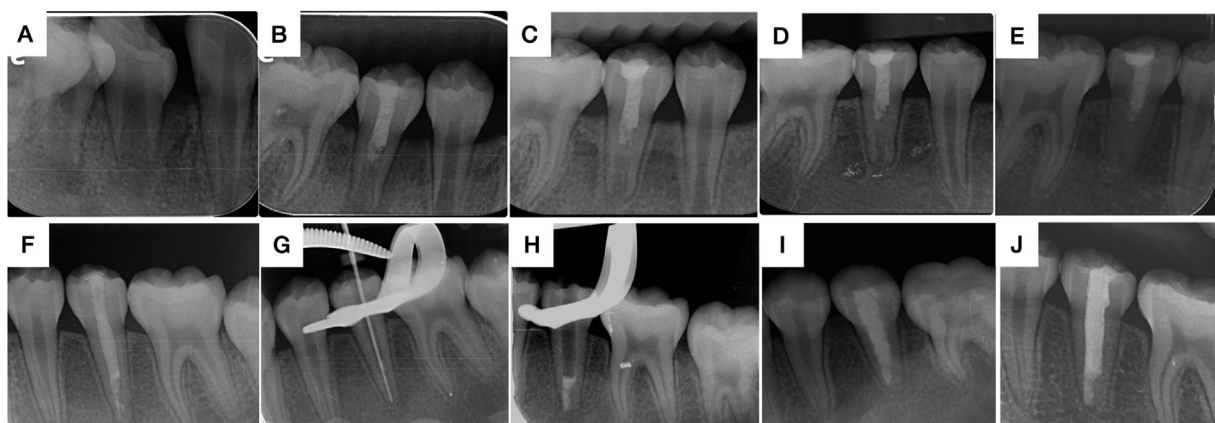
(A) Preoperative radiograph of the mandibular right posterior teeth; (B) Mineral trioxide aggregate (MTA) placement (tooth 45); (C) Six-month follow-up (tooth 45); (D) One-year follow-up (tooth 45); (E) Two-year follow-up (tooth 45); (F) Preoperative radiograph of the mandibular left posterior teeth; (G) Working length determination (tooth 35); (H) MTA obturation at apical third of canal (tooth 35); (I) Six-month follow-up (tooth 35); (J) One-year follow-up (tooth 35).
